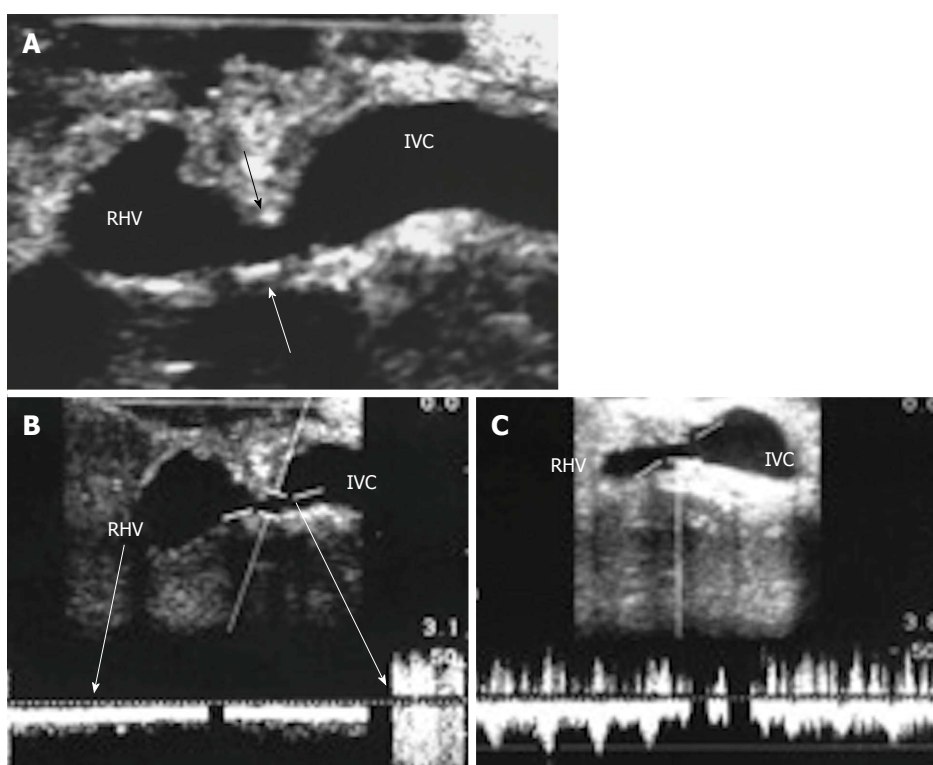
Intra-operative hepatic vein stenosis. A: Intra-operative B-mode US image showing tight stricture along the RHV anastomosis with the IVC (arrows); B: Pulsed Doppler image showing dampened intra-hepatic venous spectral flow, loss of the normal venous phasicity and anastomotic jet (> 3-fold) compared to the intrahepatic flow; C: Pulsed Doppler image after surgical revision of the RHV anastomosis demonstrating improvement of the flow with regaining the triphasic pattern respecting the cardiac cycle. RHV: Right hepatic vein; IVC: Inferior vena cava.
